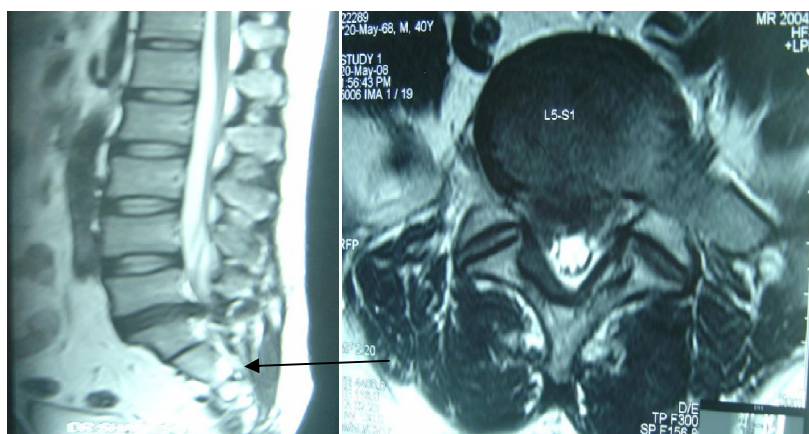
Sagittal MR image showing
